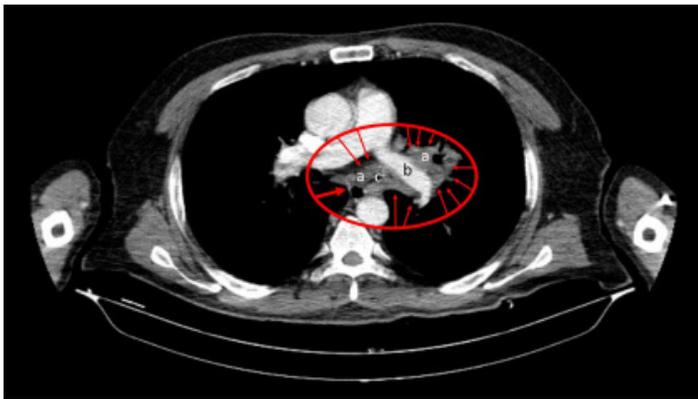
CT scan of the chest with contrast with solid lesion surrounding the left pulmonary artery and the left main bronchus. a. lung mass (9x5cm) surrounding the left pulmonary artery, b. left pulmonary artery, c. bronchus in which the lung mass causes significant narrowing
